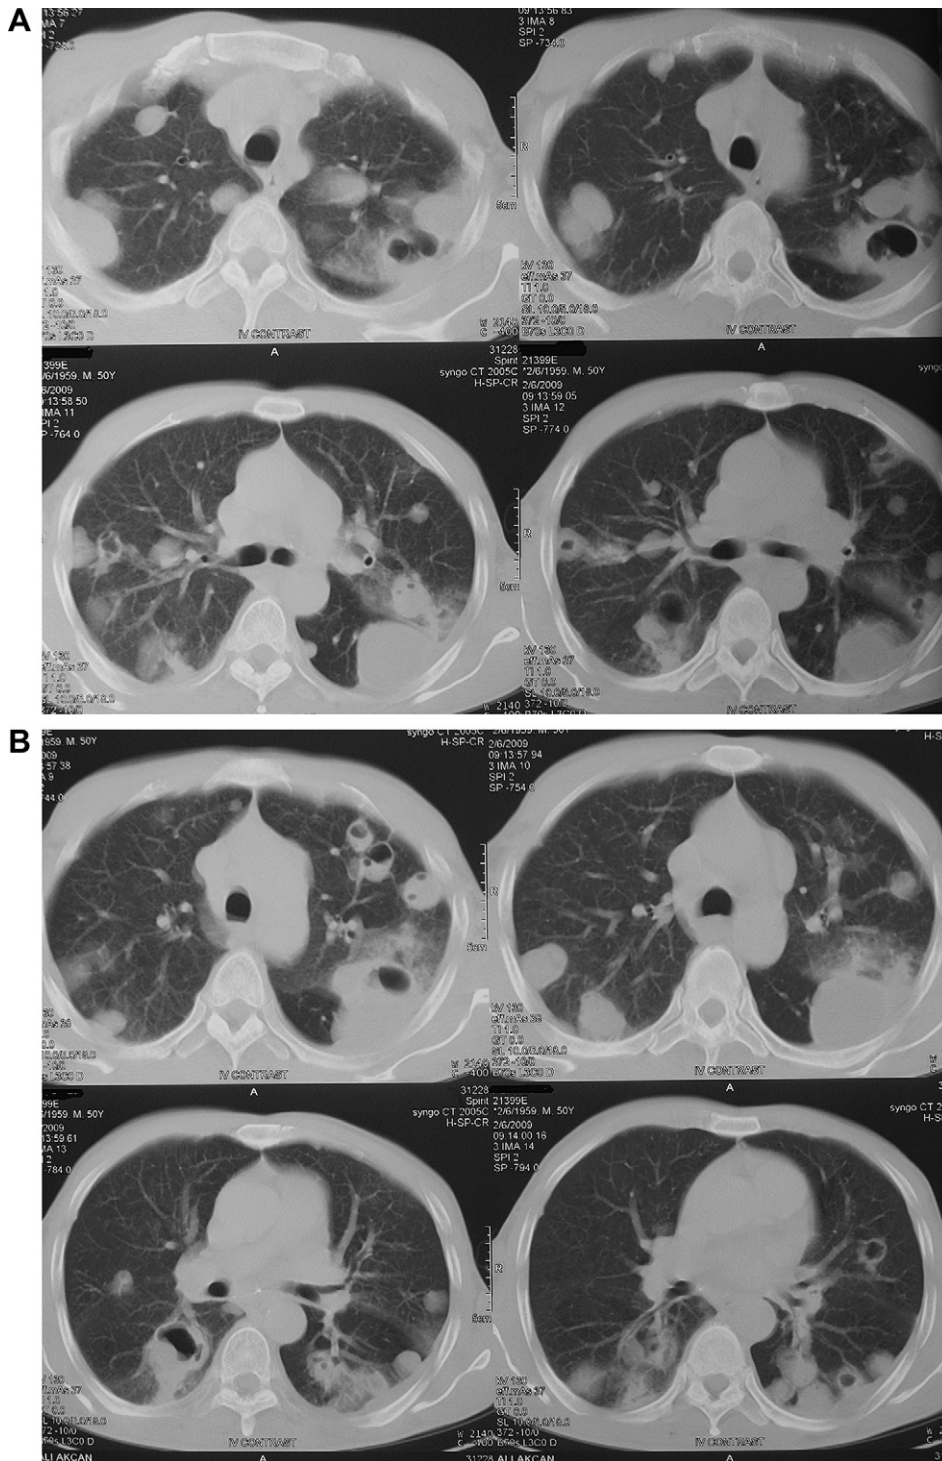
Thorax CT revealing bilateral multiple nodular lesion.
